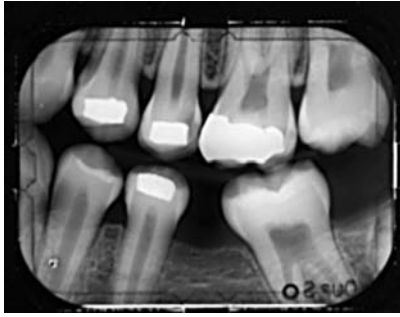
Normal Alveolar Bone Height. This radiograph shows a normal alveolar bone height that is 1.5 to 2 mm below and parallel to the cemento-enamel junction. In this example, alveolar crest is a dense radiopaque line similar in density to the lamina dura surrounding the root of the tooth.
